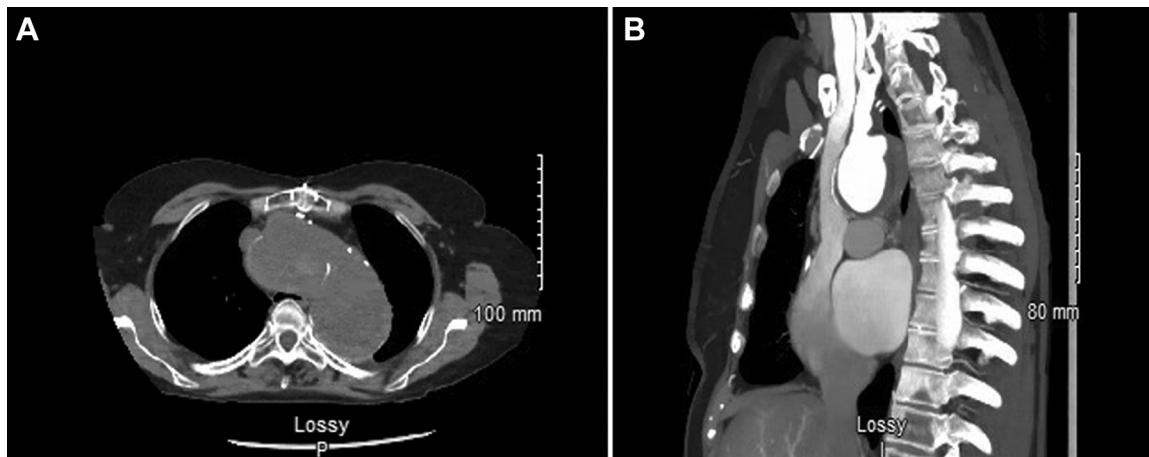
Preoperative cross-sectional computed tomography images depicting the ascending aortic aneurysm with significant compression of the proximal trachea due to a local mass effect. A, Axial view. B, Sagittal view.
